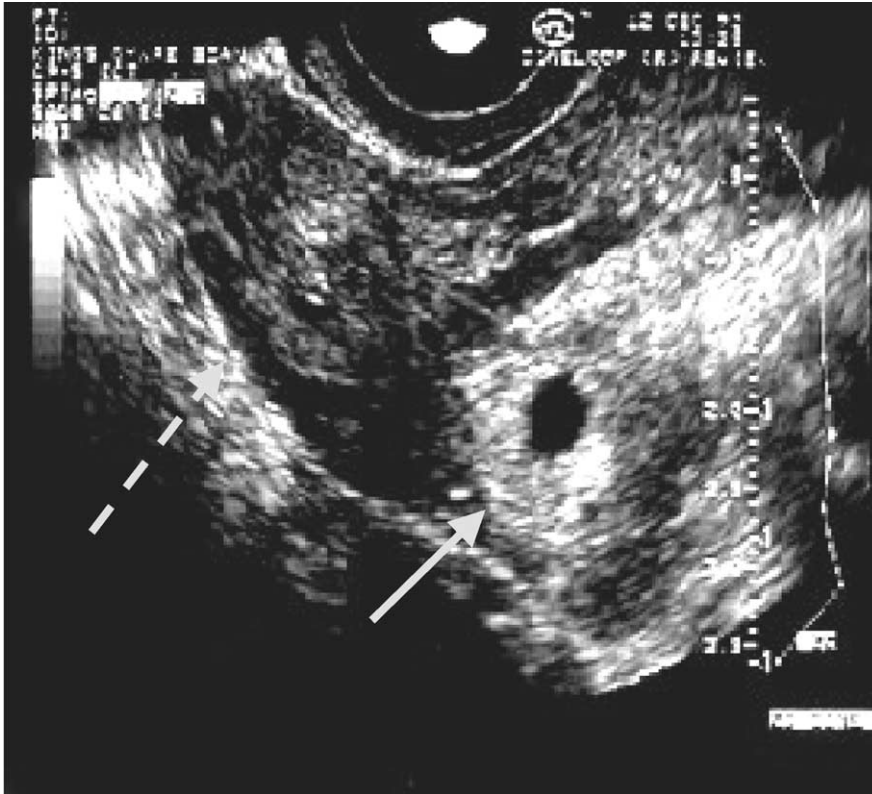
Ectopic pregnancy—'bagel' sign. Broken arrow depicts the right ovary and solid arrow shows ectopic pregnancy. Reproduced with permission from: Condous et al. *Ultrasound Obstet Gynecol* 2003; 22: 420–430.
